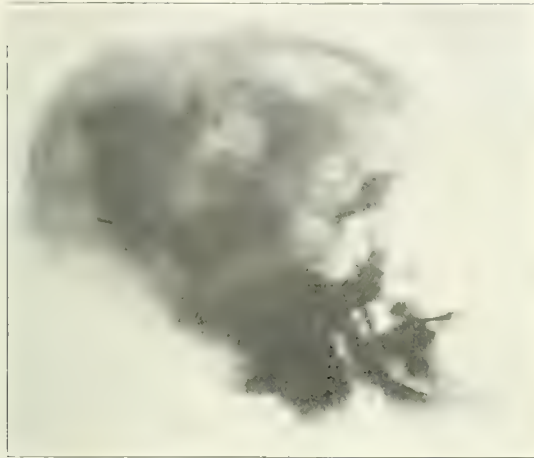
Radiograph of skull of patient in Case II showing multiple small and large metastatic foci.
